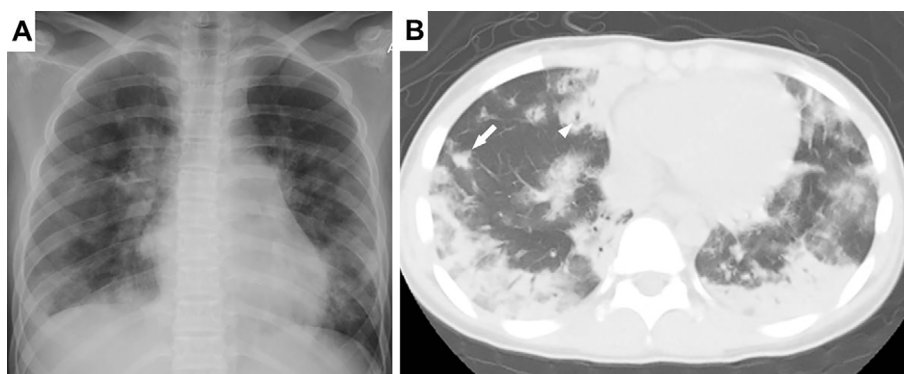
Chest X-ray and computed tomography on admission. (A) Chest X-ray shows bilateral reticular shadows. (B) Computed tomography reveals non-segmental bilateral consolidation with peripheral distribution, small nodules (arrow), and bronchial wall thickening in the bilateral lungs (arrowheads).
